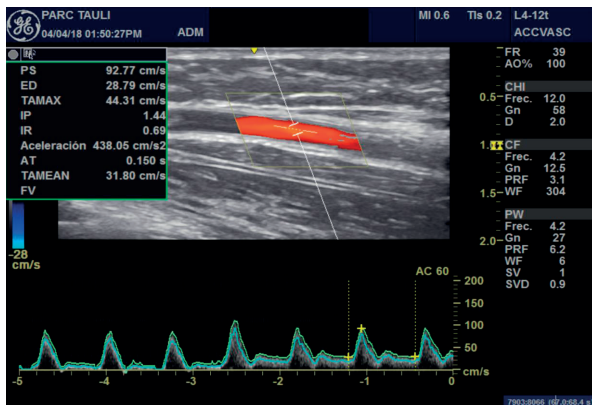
Doppler spectral wave. Pre-surgical mapping.
